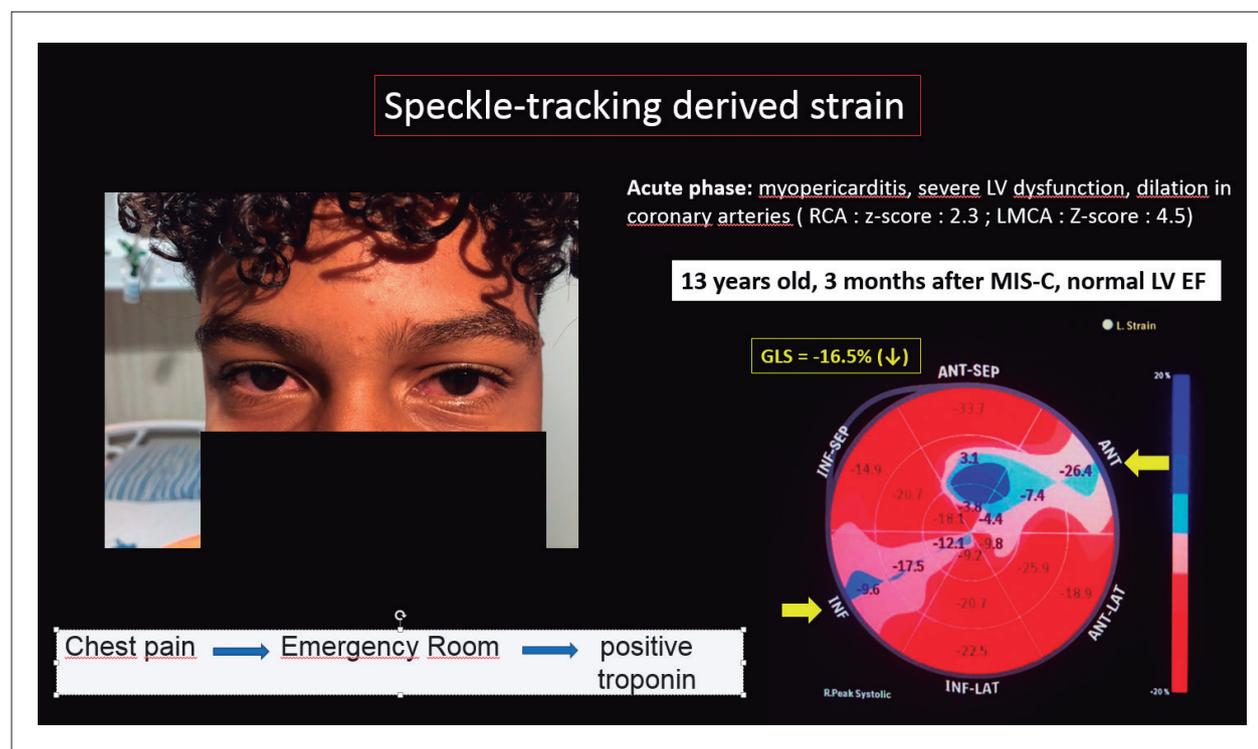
A 13-year-old teenager presenting with fever and chest pain, showed conjunctival hyperemia and positive troponin. Acute-phase echocardiogram revealed myopericarditis, left ventricular dysfunction, right coronary artery (RCA) dilation (z-score: 2.3) and small left main coronary artery (LMCA) aneurysm (z-score: 4.5). After three months of multisystem inflammatory syndrome, despite normalization of the left ventricular function (by two-dimensional echocardiogram), the patient still had abnormal myocardial strain (yellow arrows) and decreased global longitudinal strain (bull's eye-plot).
